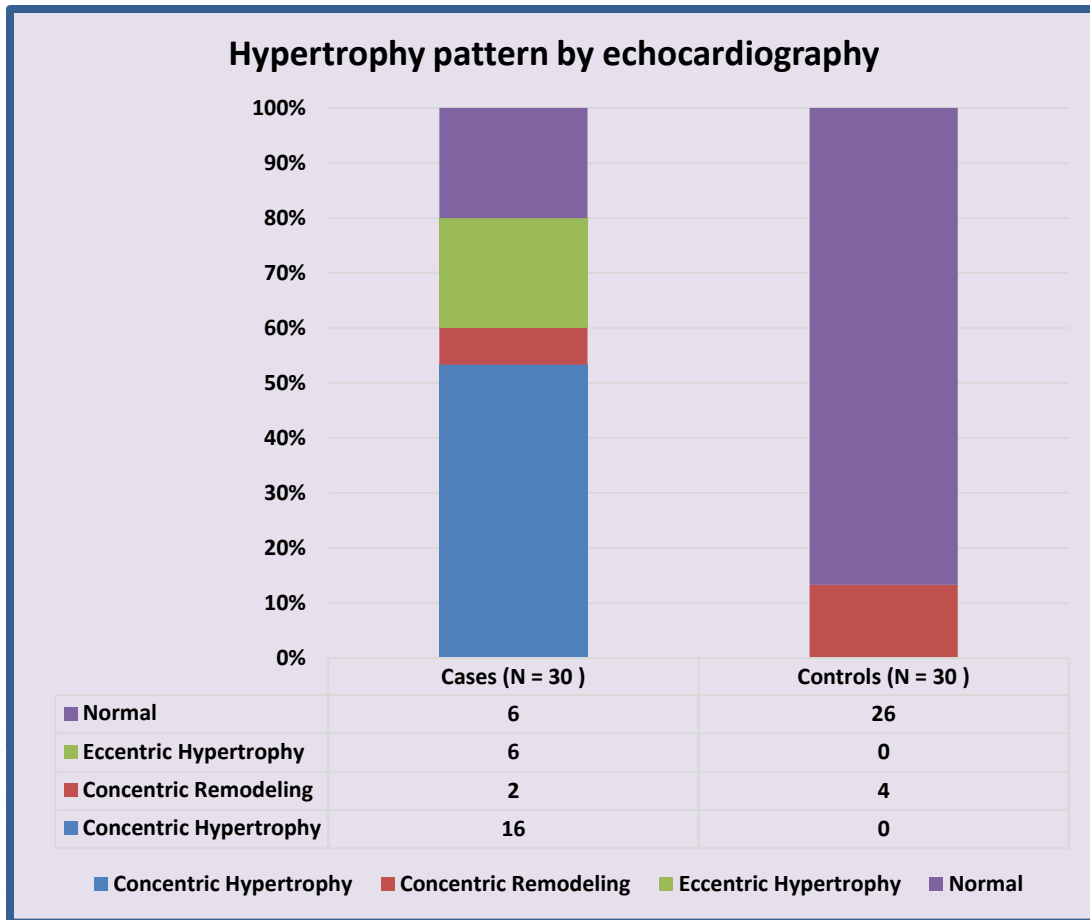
Echocardiographic parameters, 1
